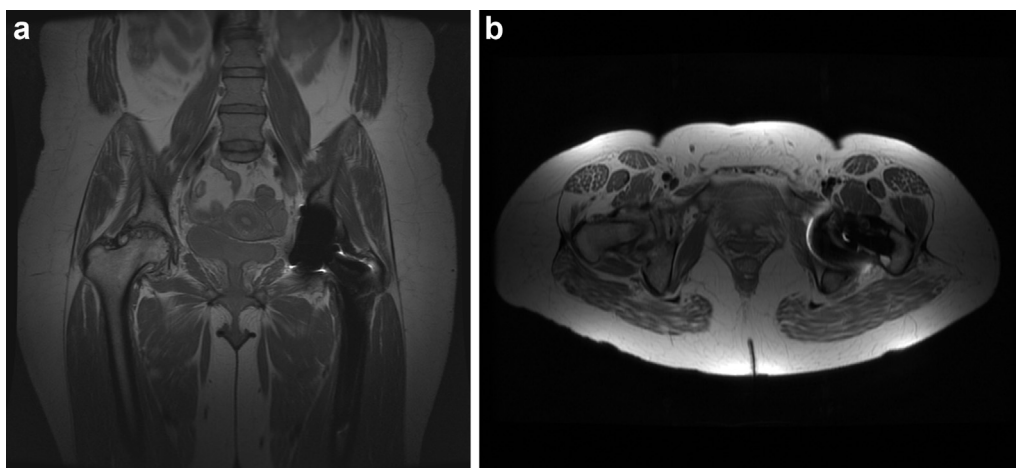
Coronal (a) and axial (b) MARS MRI demonstrating no evidence of pseudotumor or abductor insufficiency.
